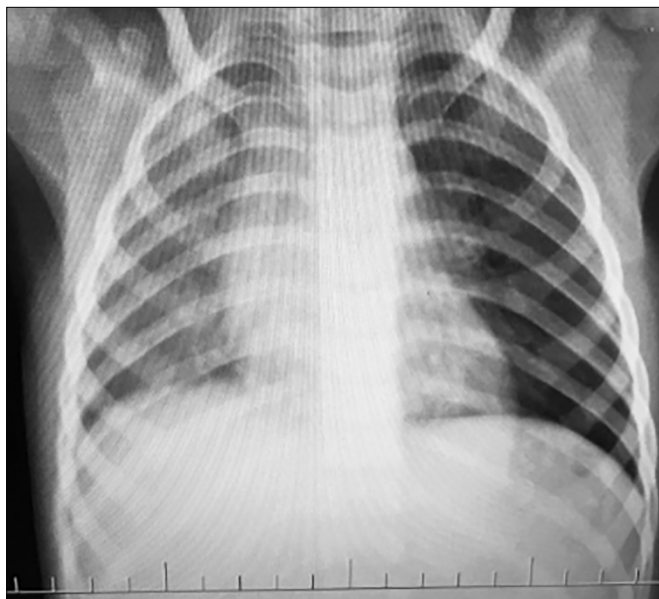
Chest X-rays: expiration phase.
